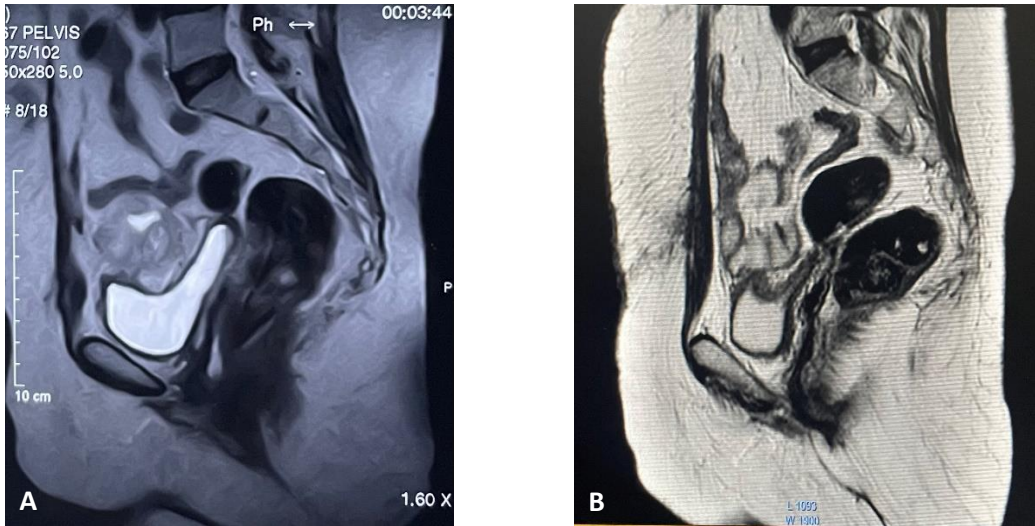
(A&B) Preoperative and post-operatively done T2 weighted MRI scans.
